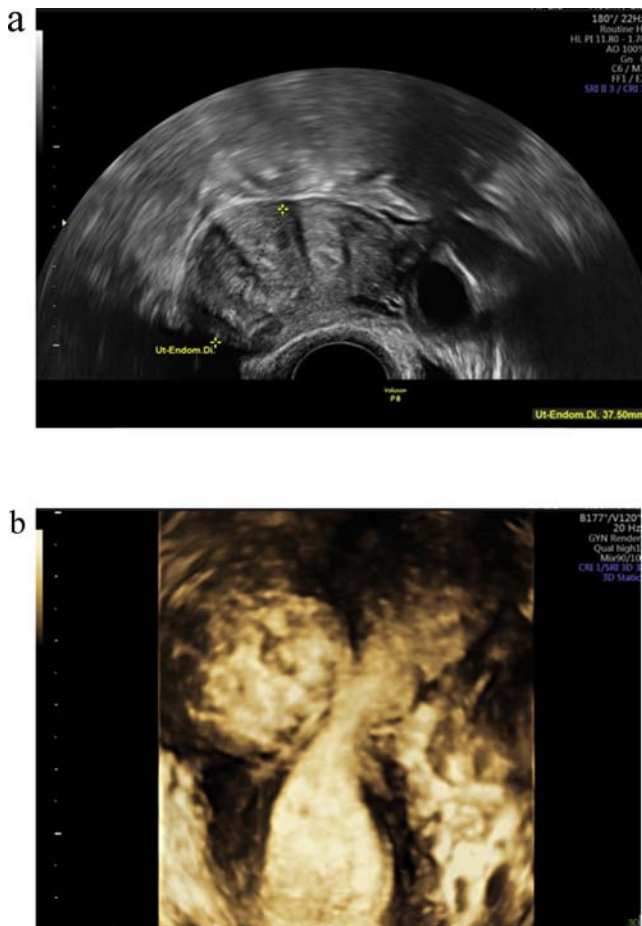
(A and B): Presentation of an intramural myoma, affecting the cavum uteri, with regular 2D vaginal ultrasound on the left hand side and with 3D vaginal ultrasound on the right hand side.
